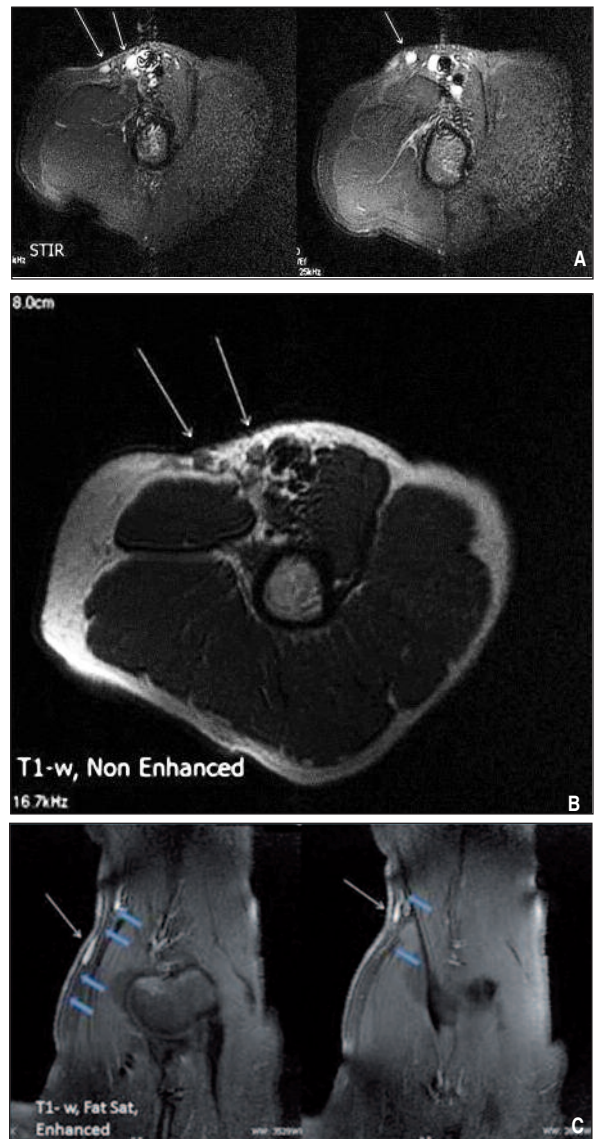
A-C: Axial STIR (a), axial non enhanced T1-weighted (b), and coronal fat saturated, T1-weighted, enhanced (c) magnetic resonance images show schwannomas (white arrows) and enhanced neural structures (blue arrows).
